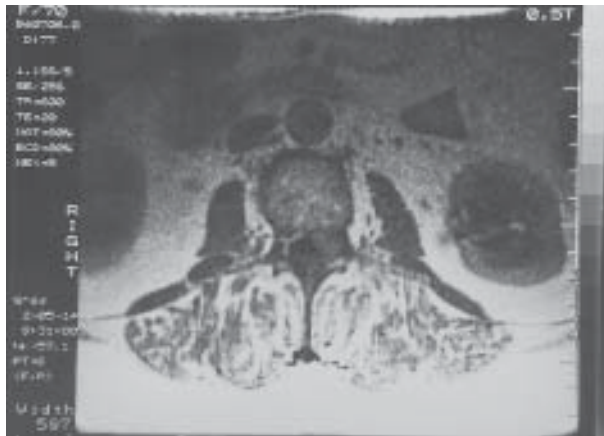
MRI scan showing dorsolateral left-sided disk extrusion at L3-L4 level.
